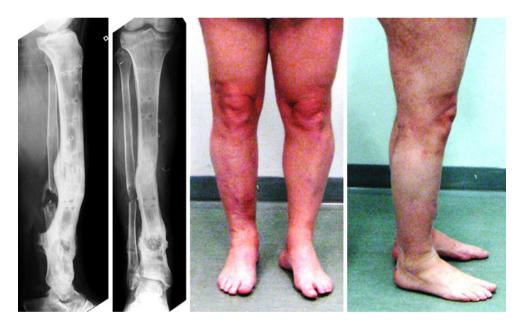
From *left* to *right* images show, Lateral and AP radiographs with good consolidation of the docking site and clinical outcome. Treatment strategy = bifocal antegrade bone transport. Treatment time = 12 months. Lengthening = 68 mm. Lengthening index = 1.76 (mo/cm)
